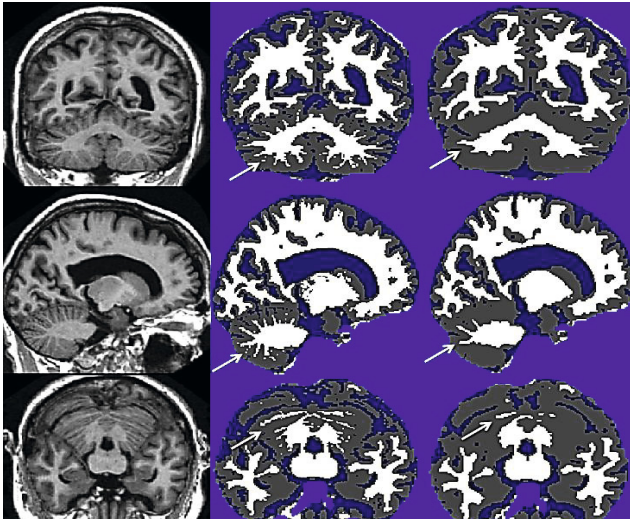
From top to bottom: axial, sagittal and coronal slice of T1-MPRAGE. From left to right: original MRI, PMC and FAST-FSL brain maps.
